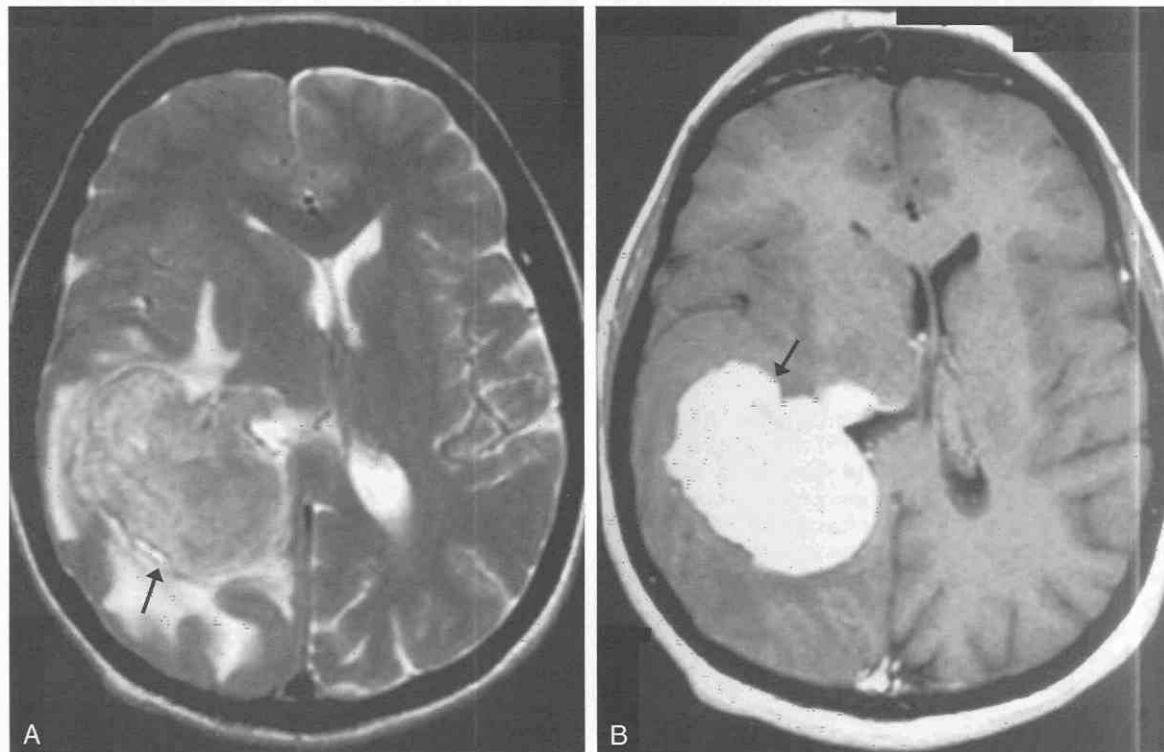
Intraventricular meningioma. A, A large round mildly hyperintense (to gray matter) tumor fills and distends the atrium of the right lateral ventricle (arrow) on this axial T2-weighted MR image. Note the dilatation of the anterior right temporal horn proximal to the obstruction caused by this mass. Edema of the surrounding white matter contributes to the right sided mass effect, which causes compression of the right frontal horn and marked shift of the septum pellucidum to the left of the midline. B, An axial T1-weighted postgadolinium image demonstrates intense homogeneous contrast enhancement of this large multilobulated intraventricular meningioma (arrow).
